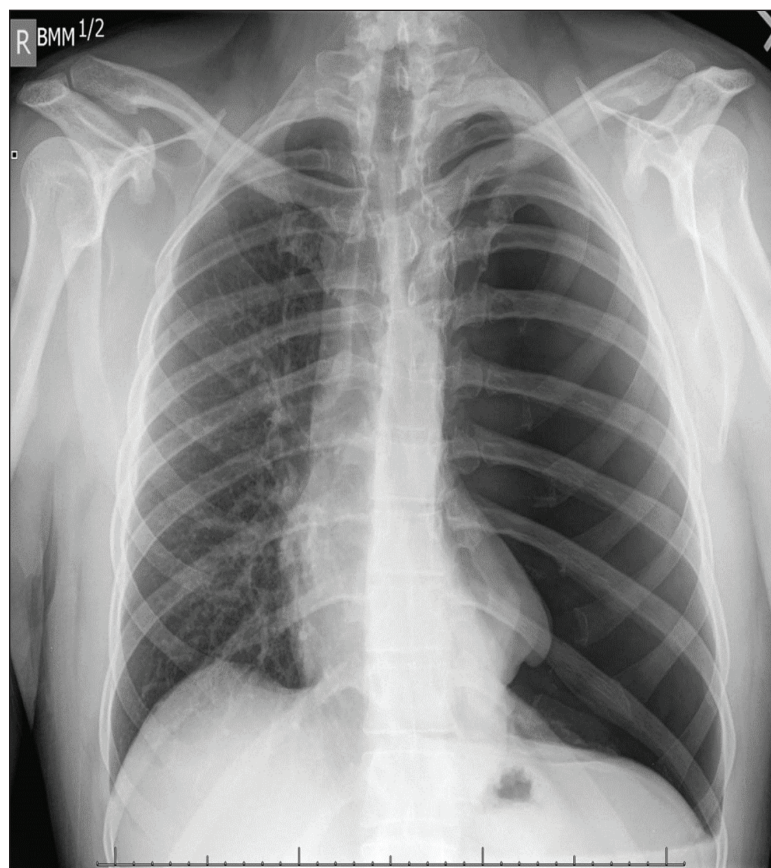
Chest X-ray showing complete translucency of left hemithorax which is devoid of lung markings consistent with large pneumothorax. There is mild contralateral mediastinal shift towards the right suggesting element of tension.
